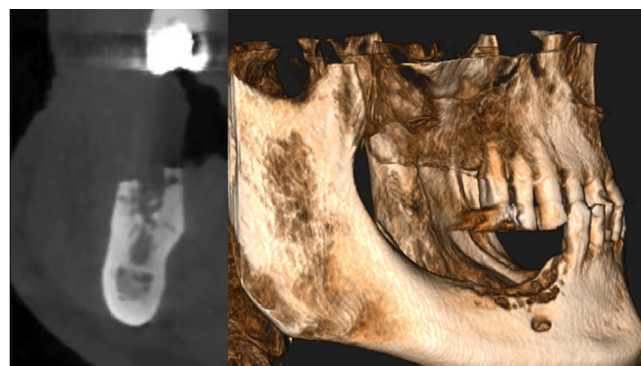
Cone beam computed tomography images of the necrotic bone.
